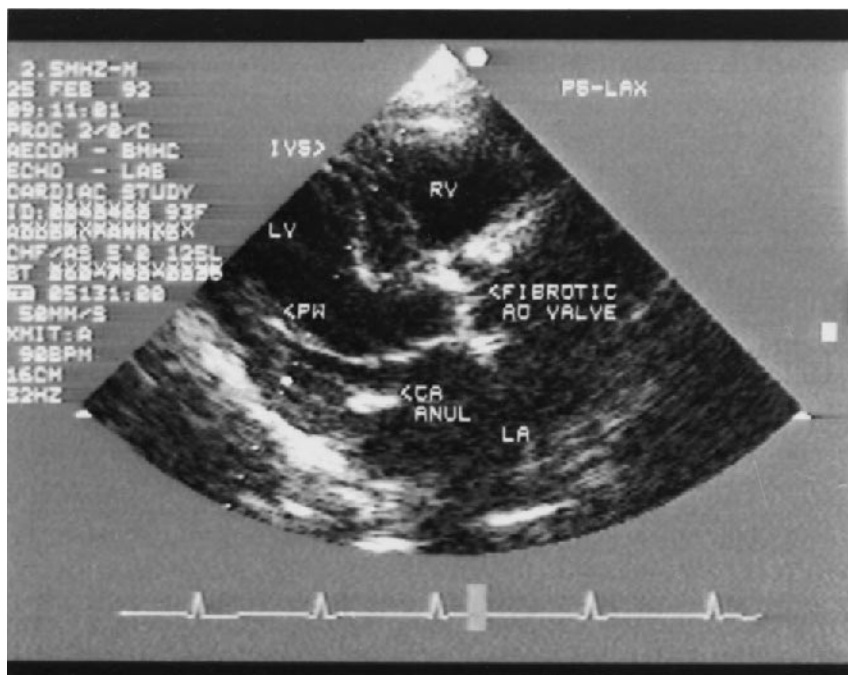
Two-dimensional echocardiographic image from a parasternal long-axis view of a 93-year-old female with aortic stenosis and moderately depressed left ventricular function showing a fibrotic aortic valve and mitral annular calcification. PS-LAX = parasternal long-axis view; RV = right ventricular cavity; LV = left ventricular cavity; IVS = interventricular septum; PW = posterior wall; CA ANUL = mitral annulus calcification; LA = left atrium; AO = aorta.
